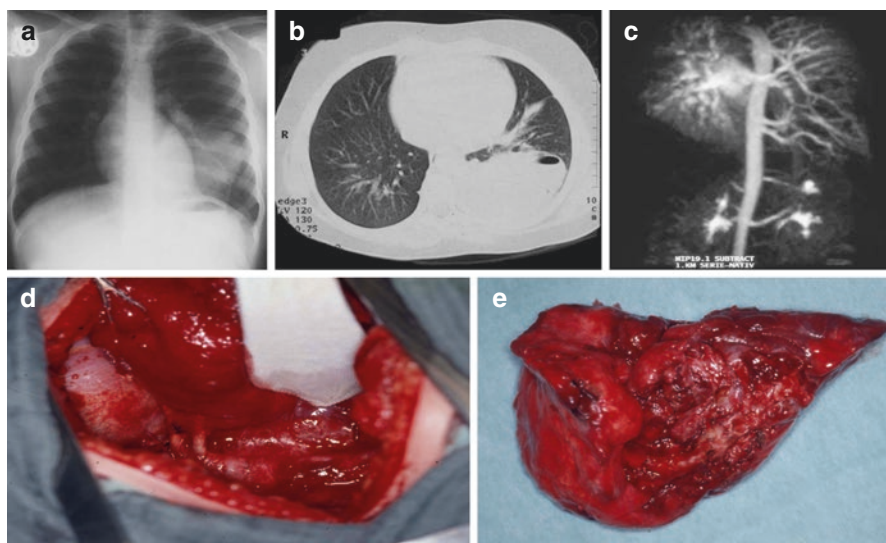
Intrapulmonary lung sequestration within the left lower lobe in a 5-year-old boy. Conventional chest X-ray (a). CT scan with compression of the healthy upper lobe (b). Vascular reconstruction showing an atypical blood supply with two arteries from the aorta (c). Intraoperative view on the two arteries within the inferior pulmonary ligament (d). Completely resected lower lobe (e)
